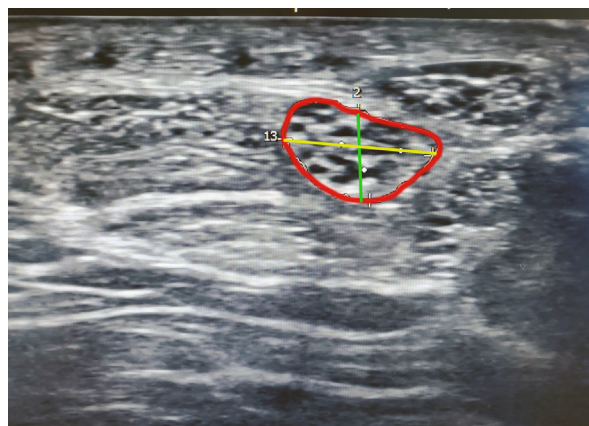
Image of median nerve and ultrasonography measurements. The red line represents the outline of the nerve used to calculate the CSA. The green line denotes nerve height. The yellow line indicates nerve width.
